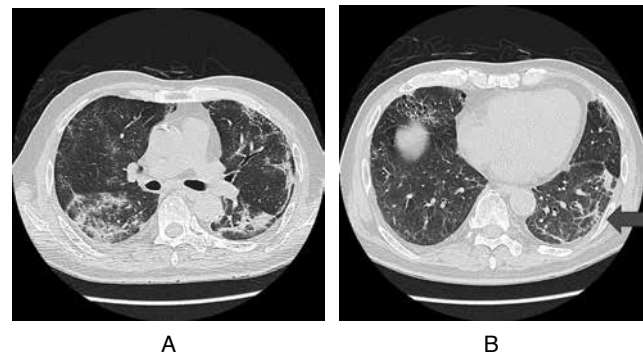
Chest CT during the recovery phase
